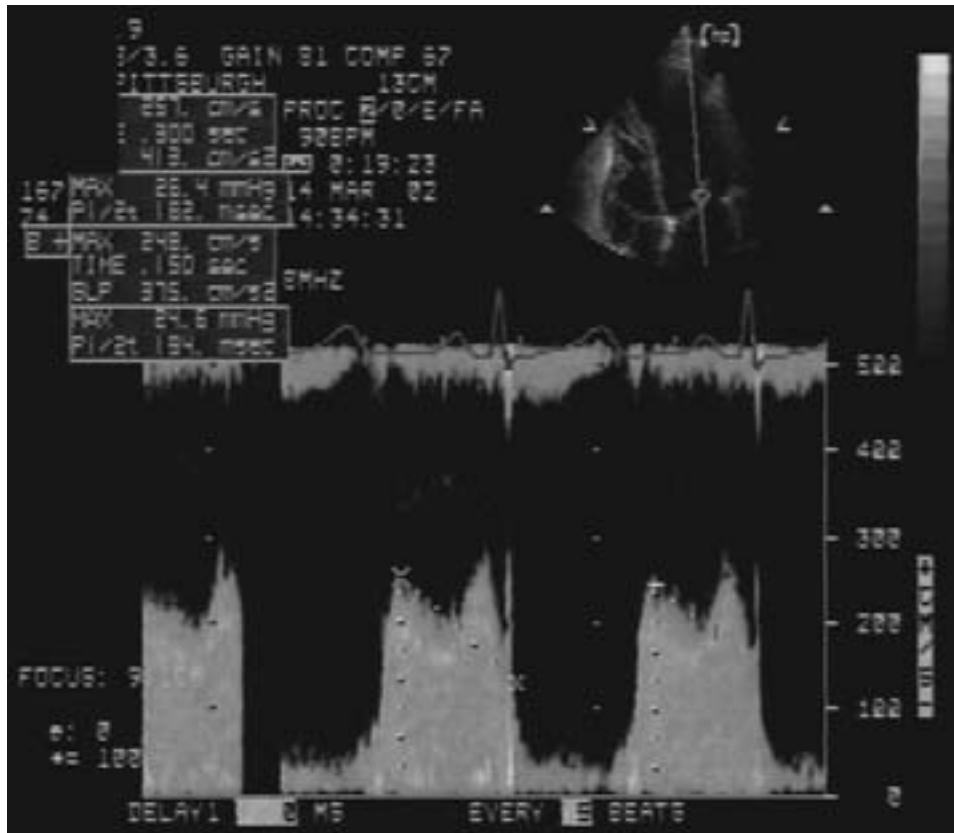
TTE CW Doppler signal of MV diastolic flow profile at rest, pressure half-time = 182 msec, MVA = 1.2 cm<sup>2</sup>, mean gradient = 14 mmHg.
